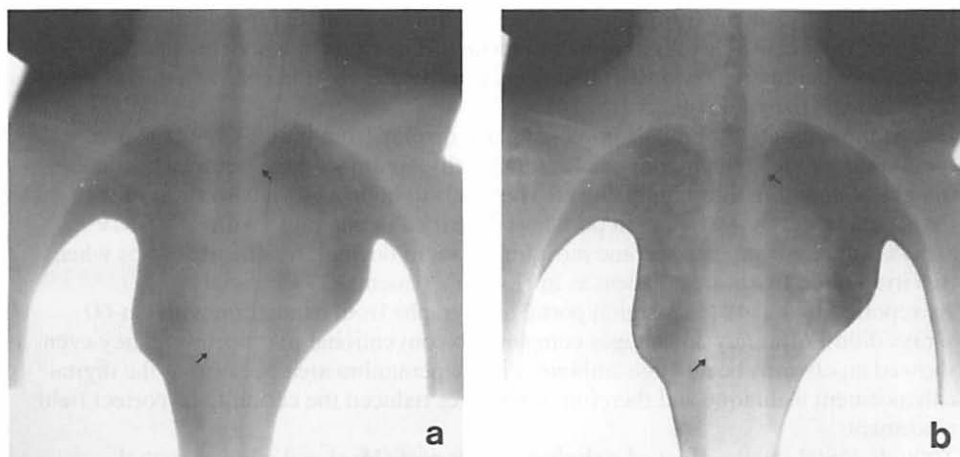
15 MV portal films of a patient with mantle field and lung blocks. The digital radiograph (b) yields better overall quality than the conventional film-screen image (a).
